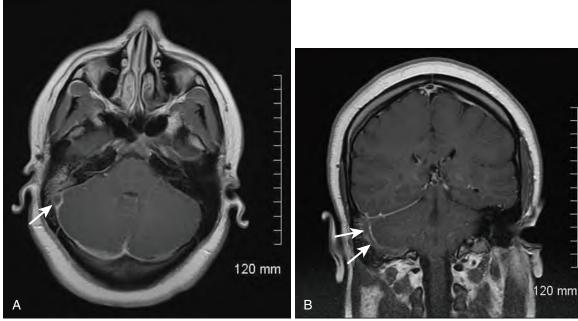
Gadolinium-enhanced T1-weighted images in the axial (A) and coronal (B) planes demonstrating extensive filling defects of the right sigmoid sinus (arrows) representing thrombosis and associated with adjacent right mastoiditis. (Courtesy Stanley Lu, MD, Monmouth Medical Center, Long Branch, NJ.)
